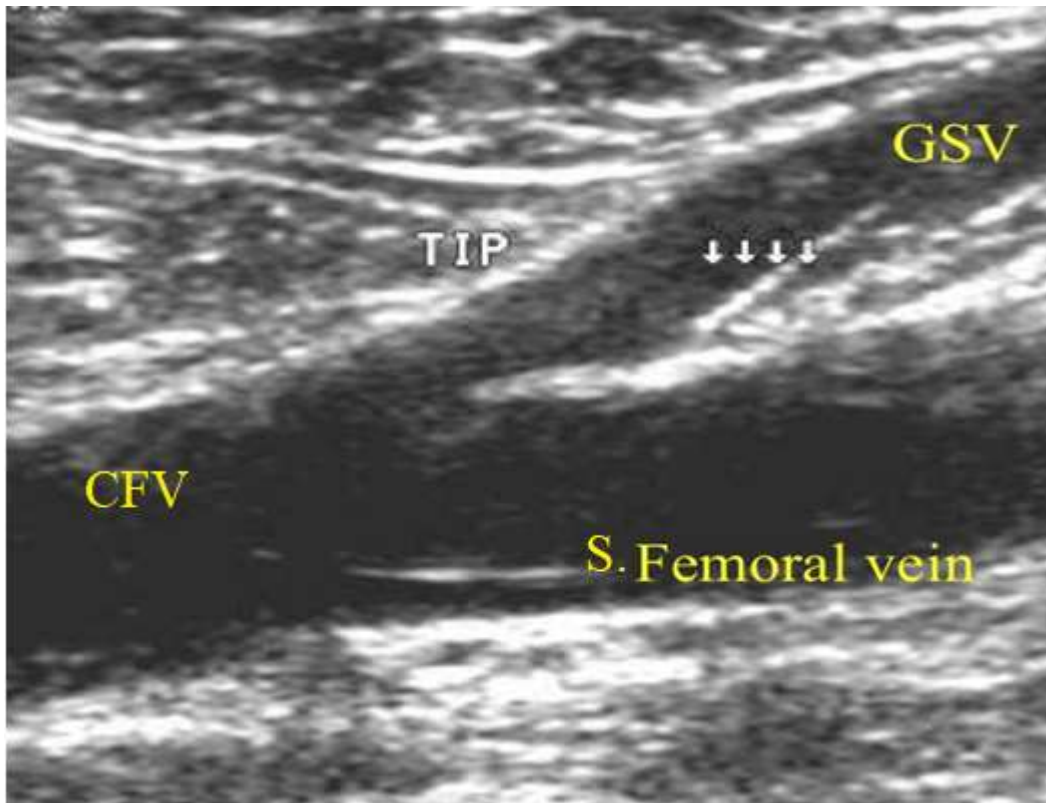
Ultrasound shows the tip of the sheath is seen about 2 centimeters distal to the saphenofemoral junction.
